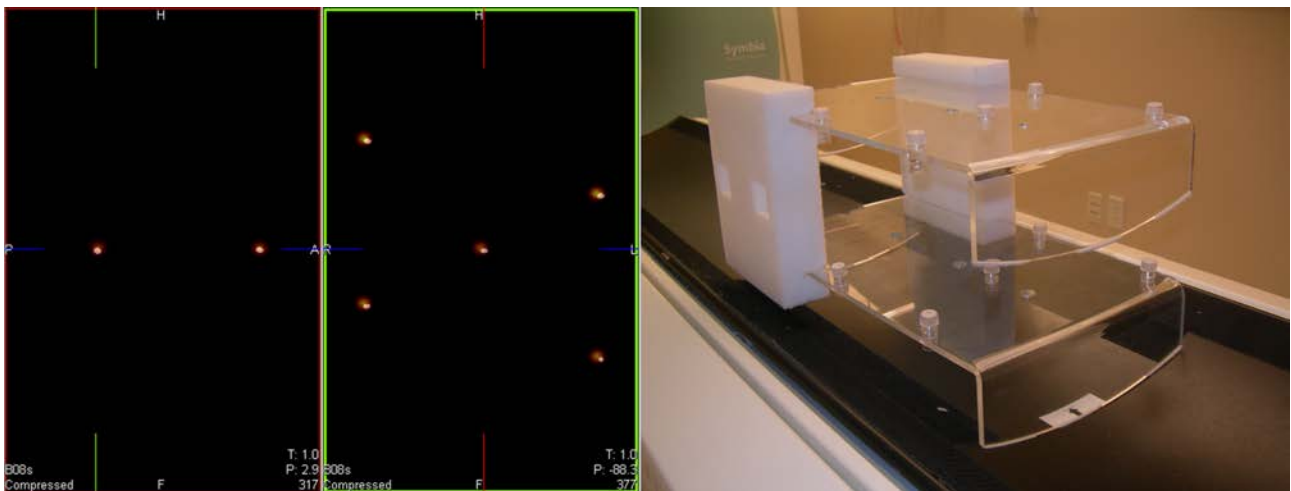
SPECT/CT registration tool from a manufacturer, which includes ten point sources (right) seen in the fused SPECT and CT images (left and middle).
